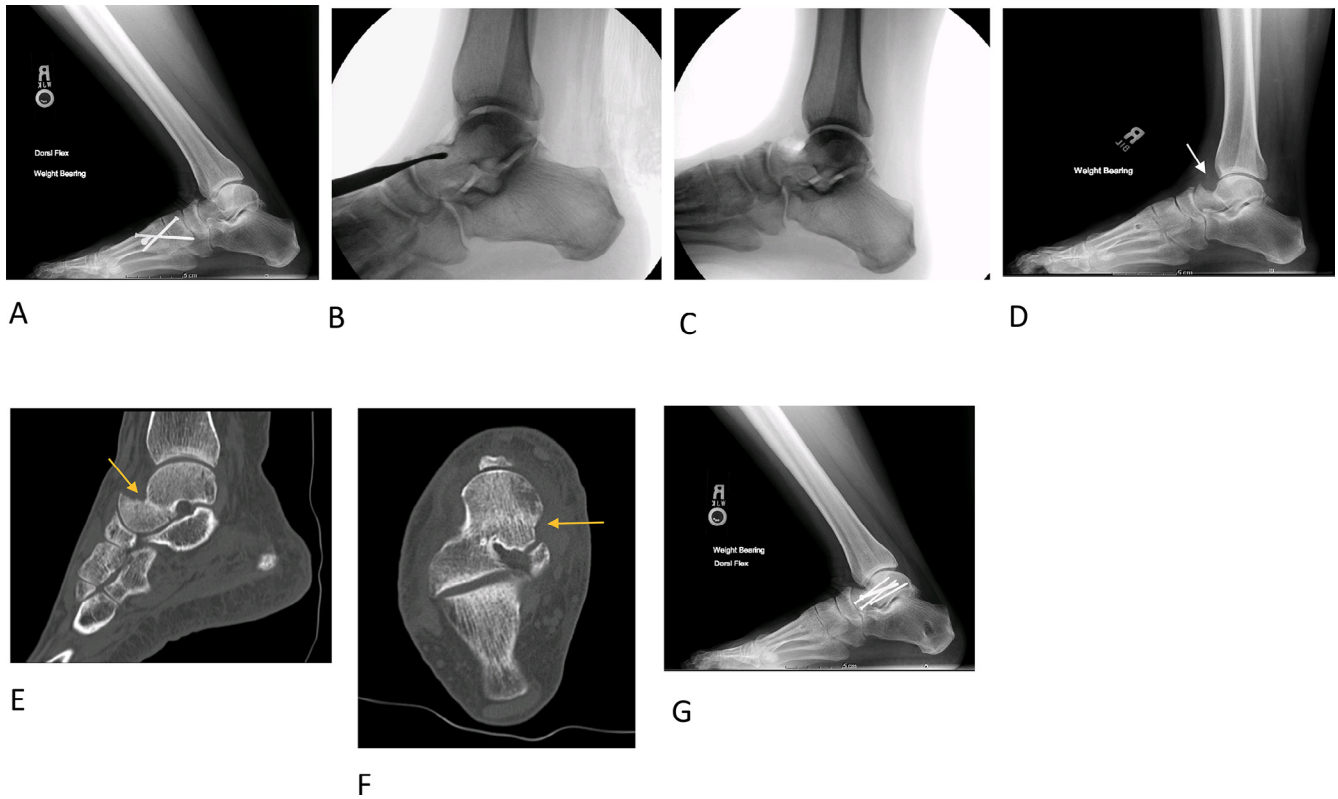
A 45-year-old woman with right ankle cheilectomy complicated by a talar neck insufficiency fracture. (A) The preoperative lateral radiograph of the ankle in dorsiflexion demonstrates surgical screws transfixing the first tarsometatarsal joints and the first 2 metatarsals from a prior Lapidus procedure for hallux valgus. There is no radiographic evidence of motion restriction. The patient subsequently underwent open ankle cheilectomy based on a clinical diagnosis of anterior ankle impingement and hardware removal (see the 2 intraoperative fluoroscopic images in B and C). (D) Lateral view of the radiograph of the right ankle 6 weeks after surgery demonstrates a sclerotic line below the talar cheilectomy site, concerning for a fracture. This was confirmed by computed tomography with sagittal (E) and axial (F) images demonstrating a sclerotic line at the talar neck extending from the site of prior talar cheilectomy to the middle facet of the subtalar joint, consistent with a subacute talar neck insufficiency fracture (arrows). The patient subsequently underwent open reduction and internal fixation of the talar neck fracture (G). In both E & F, the arrows are pointing to the sclerotic line at talar neck.
